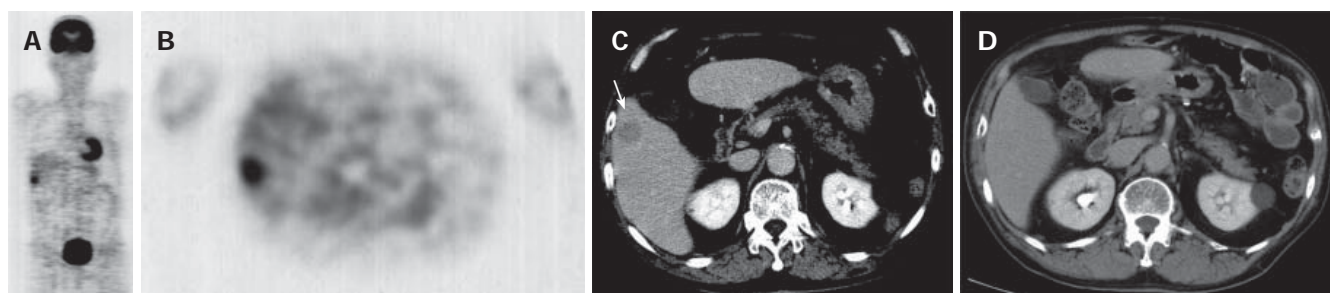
A, B: Whole body F-18 fluorodeoxyglucose (FDG) positron emission tomography (PET) scan showed a 3-cm spherical mass in the right lobe of the liver. A: Coronal sectional view, B: horizontal sectional view. C: Enhanced CT showed a 3-cm spherical low-density mass (arrow) in the right lobe of the liver. D: Another enhanced CT performed 3 mo after targeted liver biopsy showed complete resolution of the mass.
